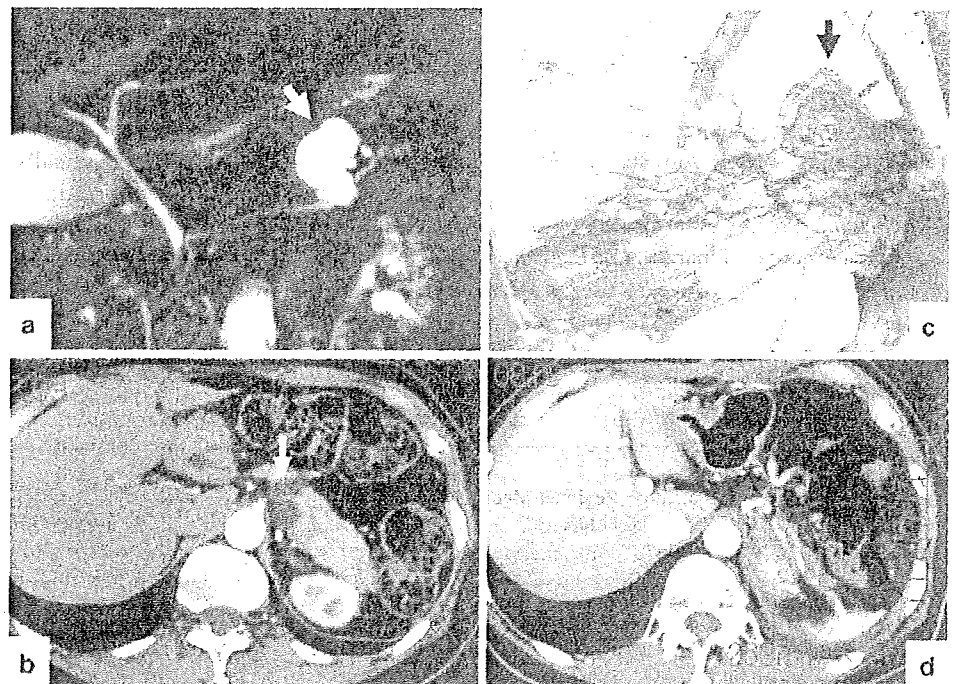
A case of branched type intraductal papillary mucinous neoplasm who underwent spleen and gastrosplenic ligament preserving pancreatectomy. a MRCP, b CT before operation, c the dissected distal pancreas and tumor, d CT 1 week after operation, *arrow* tumor
